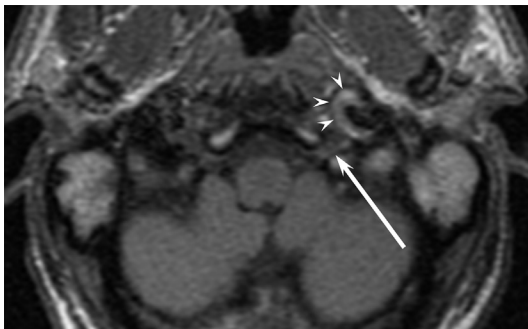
Vertebral artery dissection causing hypoglossal paralysis. T1-weighted noncontrast image demonstrates crescentic region of intrinsic T1-weighted shortening (*arrowheads*) surrounding a high cervical ICA, indicating dissection. Notice its proximity to the hypoglossal nerve and canal (*arrow*).
